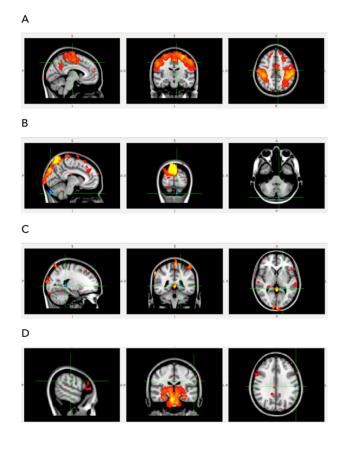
Functional magnetic resonance imaging at resting state.
